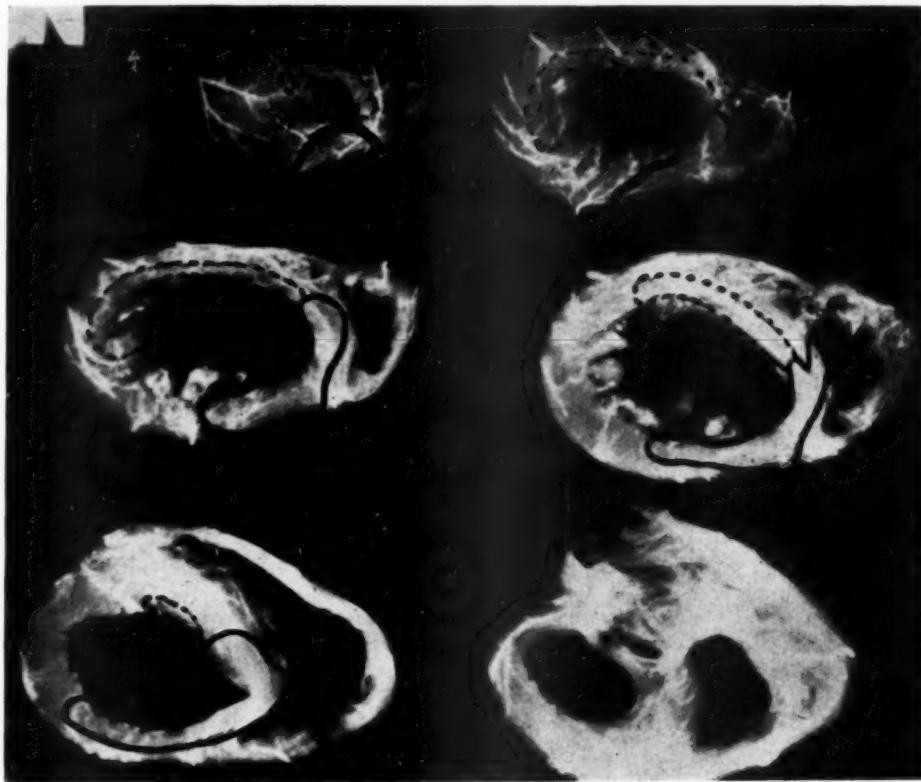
Roentgenogram of injected heart in Case 59 with recent posterior infarct demarcated by solid lines and old anterior infarct by broken lines.
